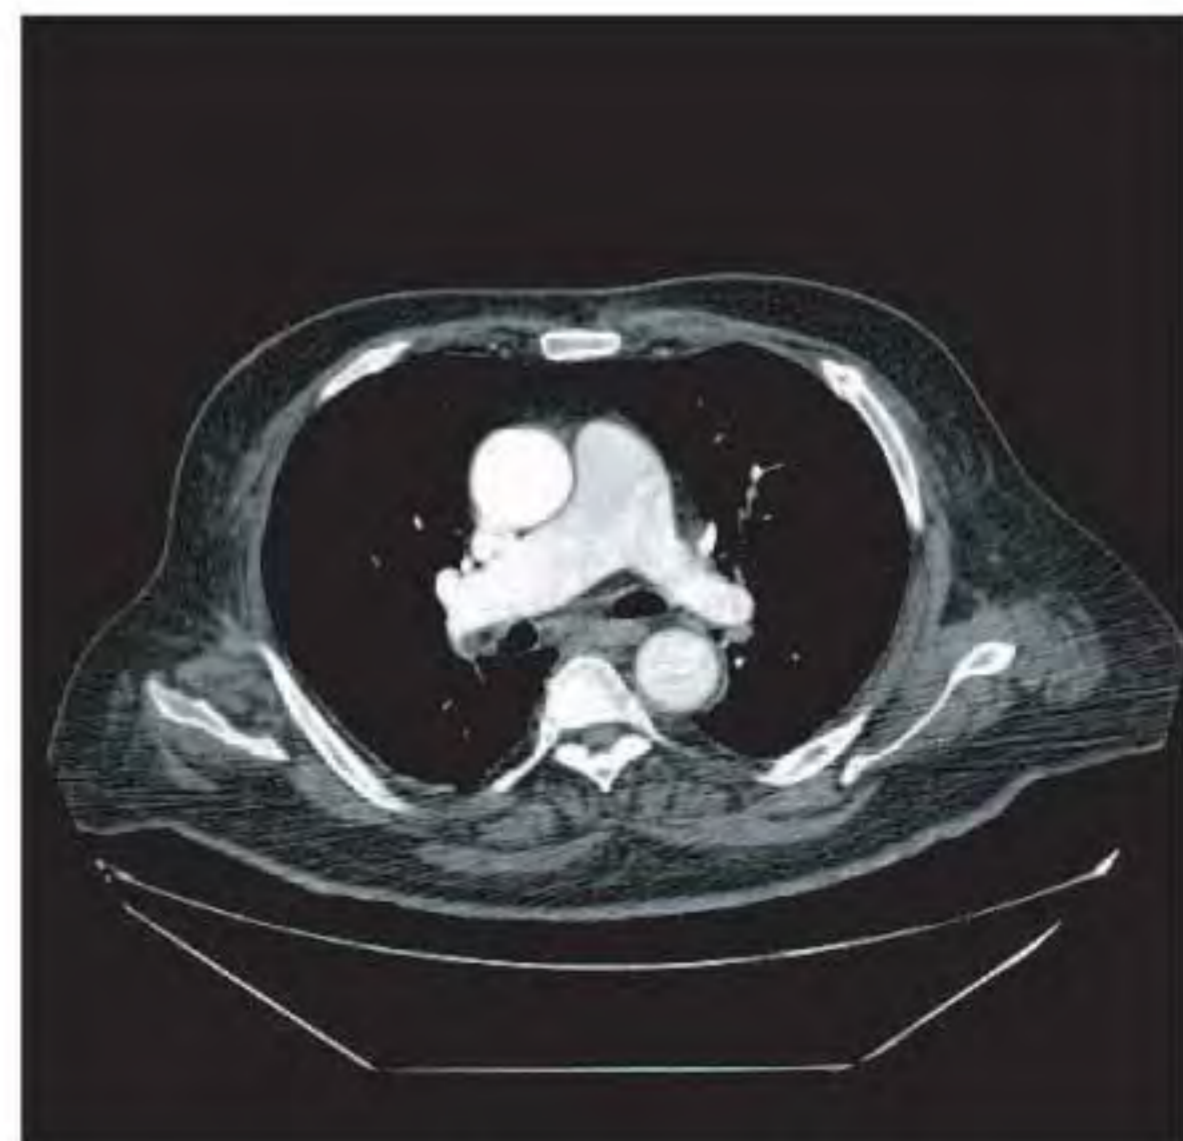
CT angiogram of chest, 25 days after thrombolysis. No embolus in the Pulmonary artery main branches
